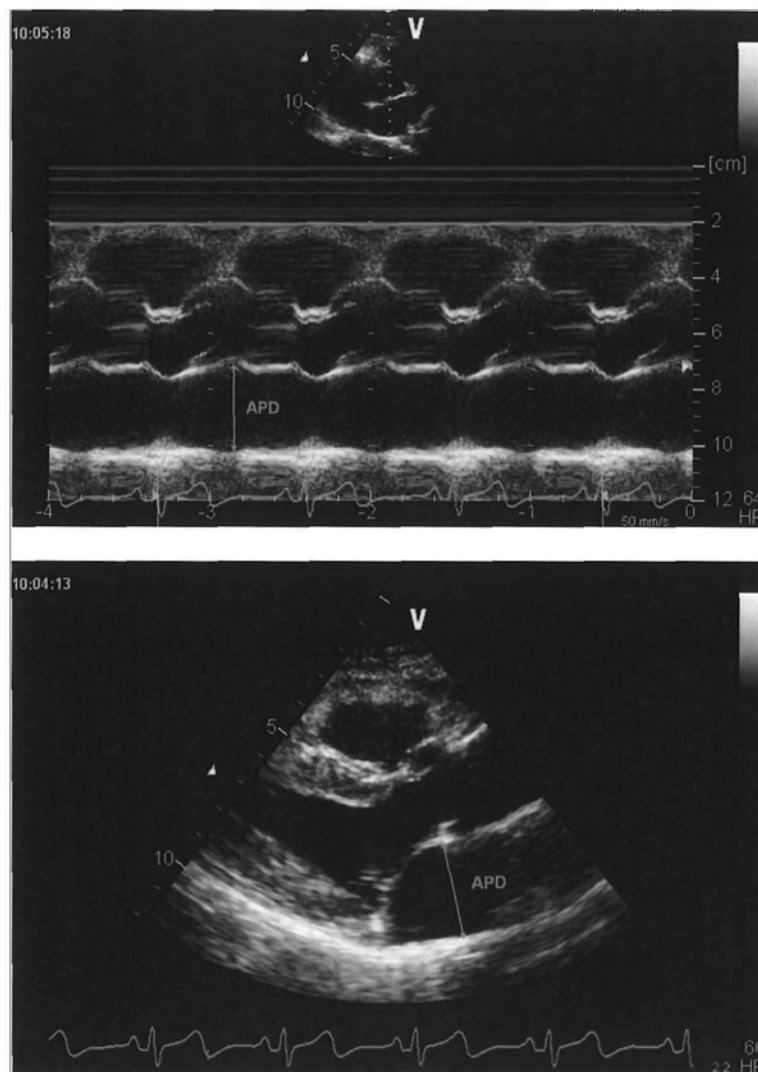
Measurement of LA anteroposterior dimension. The linear dimension of LA can be measured either by M-Mode echocardiography (Top) or two-dimensional echocardiography from parasternal long-axis view (bottom). APD, anteroposterior dimension.
